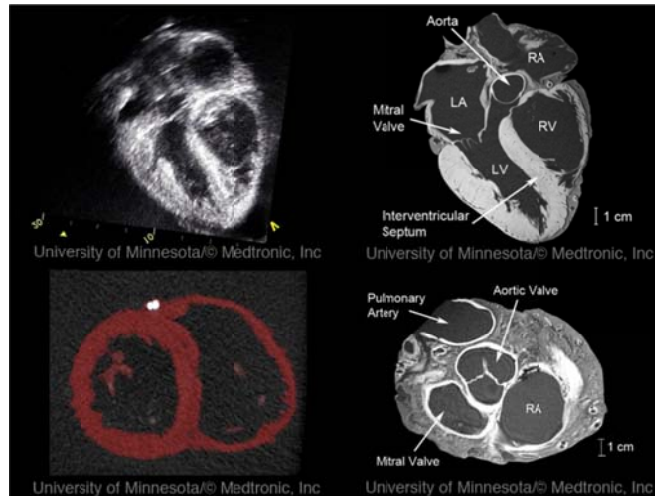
Images from perfusion fixed hearts from the Visible Heart® library: 1) a long axis four-chamber cardiac ultrasound view (upper left panel); 2) a long axis four-chamber MRI view (upper left panel); 3) a short axis CT view at the ventricular level showing calcium deposition in the anterior interventricular artery, the myocardium has been colored red in post processing to ease viewing (lower left panel); 4) a short axis MRI view at the valve level (lower right panel). Modified from Eggen et al. [13].
